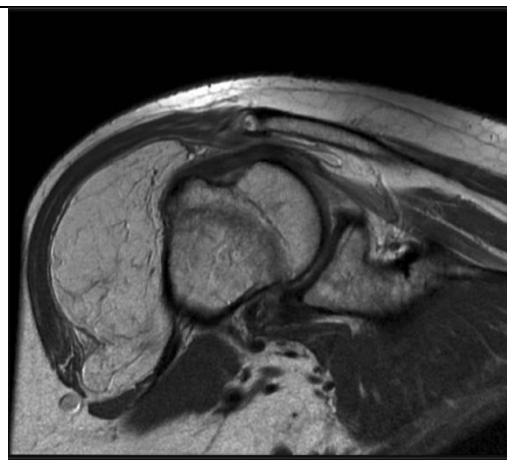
Signal intensity of the tumor on magnetic resonance Imaging. A low signal intensity or iso-intensity to skeletal muscle at the center and high signal intensity at the periphery of the lesion seen.
